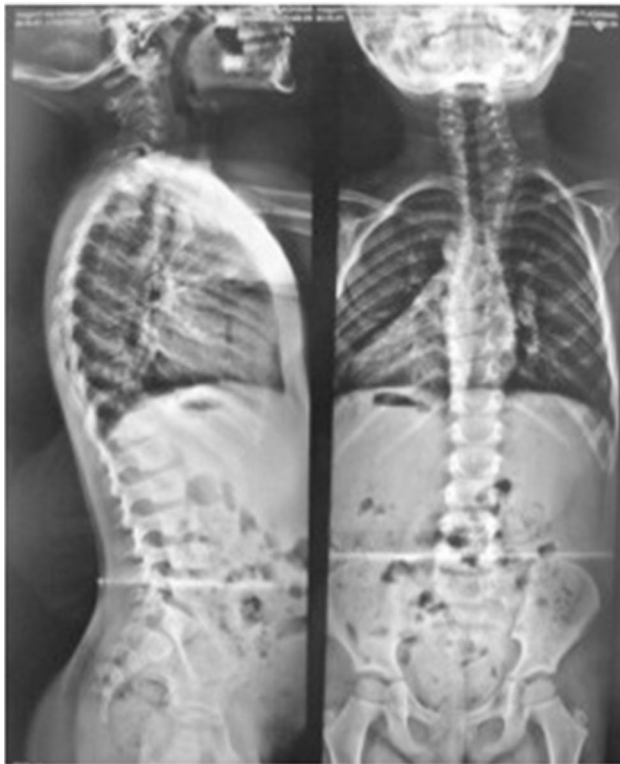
Plain film X-ray of twin A on presentation demonstrating a right T1 hemivertebra and left T8 hemivertebra, both of which were fused to adjacent vertebra
